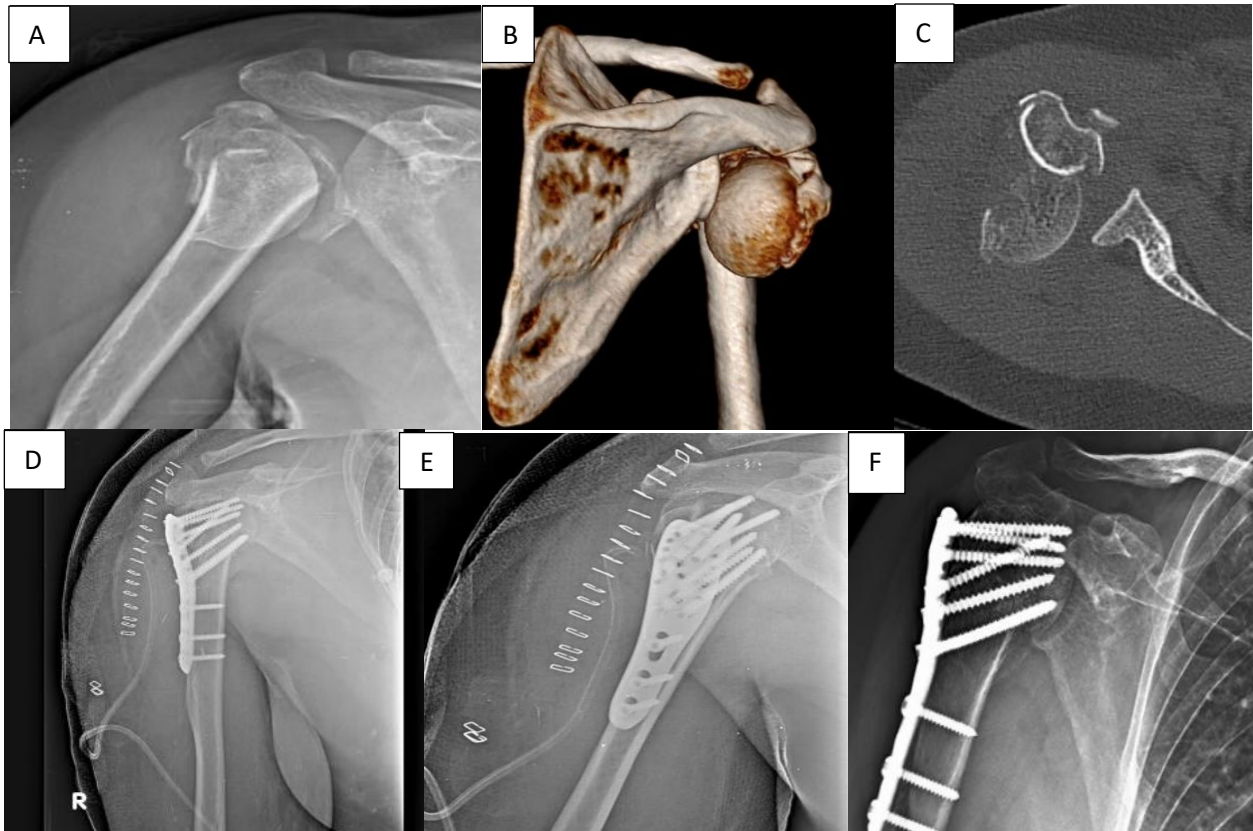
(A-C) 45 years old - pre op X-ray- patient presented to the hospital after 6 days following the injury; (D-E) immediate post op X-ray showing good reduction and implant in satisfactory alignment; (F) X-ray at the end of 6 months showing avascular necrosis of humeral head-patient had pain and severe restriction of motion with a CMS score of 45.
